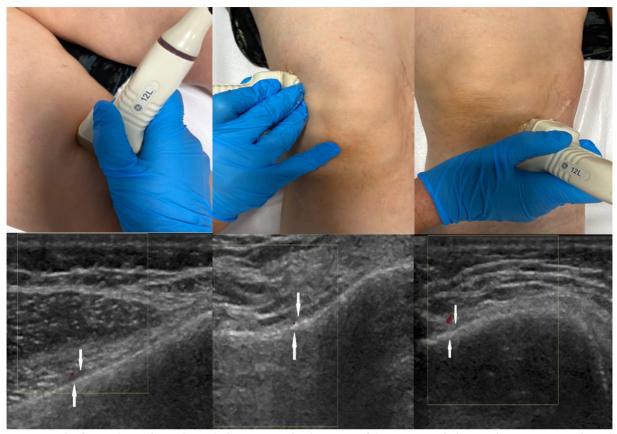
The figure shows the probe and ultrasonographic locations of the superomedial genicular nerve, superolateral genicular nerve, and inferomedial genicular nerve, respectively.
